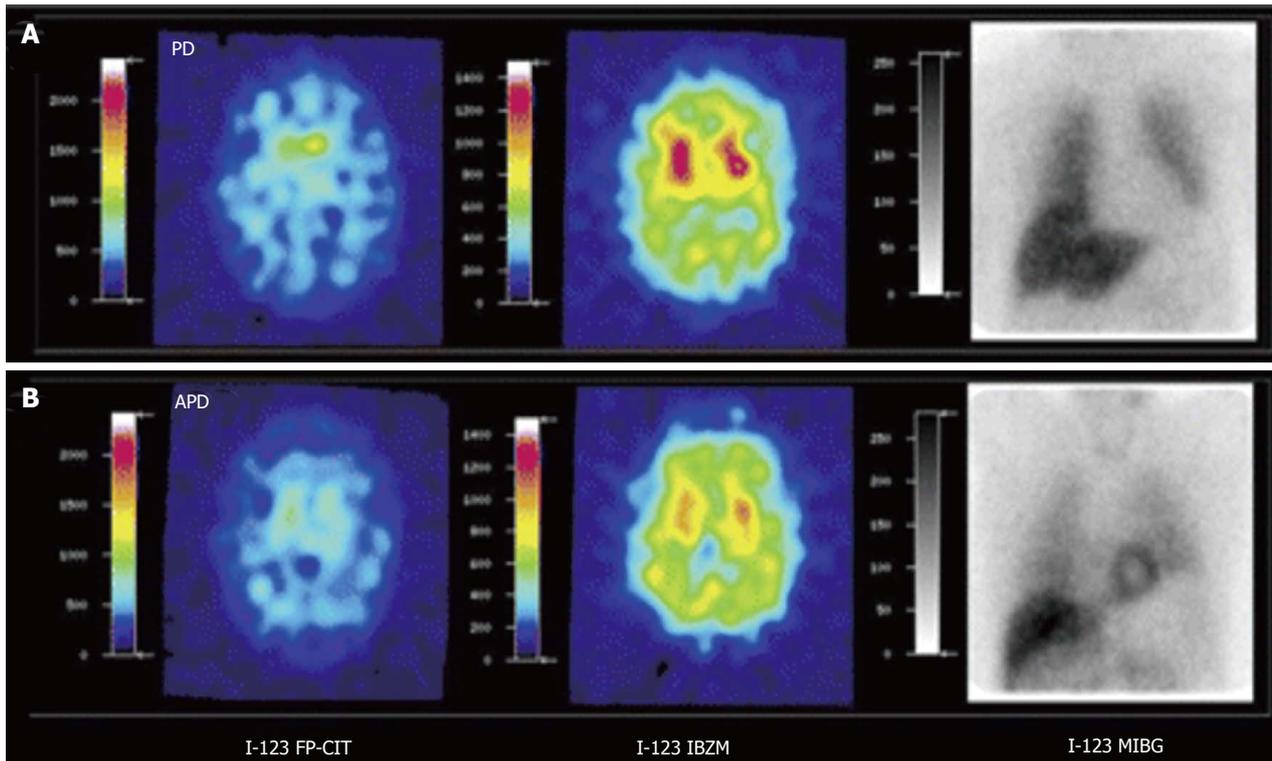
[^{123}I]FP-CIT, [^{123}I]IBZM and cardiac SPECT imaging [^{123}I]MIBG of Parkinson's disease (A) and atypical parkinsonism (B). Striatal [^{123}I]FP-CIT is decreased in both PD and APD. Striatal D₂ receptor binding is normal in PD but decreased in APD. Myocardial sympathetic SPECT signal is decreased in PD but normal in APD. PD: Parkinson's disease; APD: Atypical parkinsonism; SPECT: Single photon emission computerized tomography. (Originally published in the JNM. Südmeyer M, Antke C, Zizek T, et al. *J Nucl Med* 2011; 52: 733-740. © by the Society of Nuclear Medicine and Molecular Imaging, Inc.)
